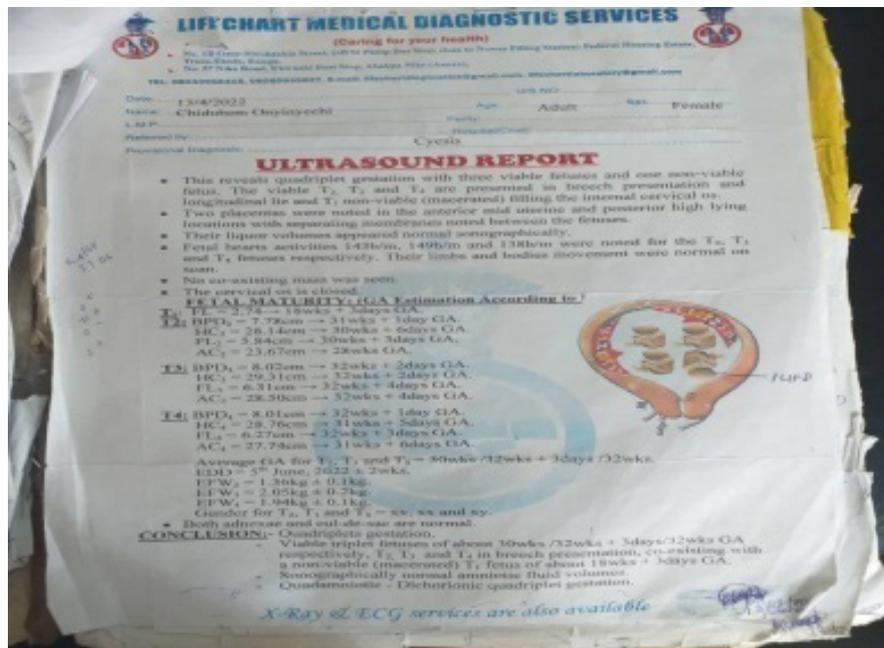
Ultrasound reports.
